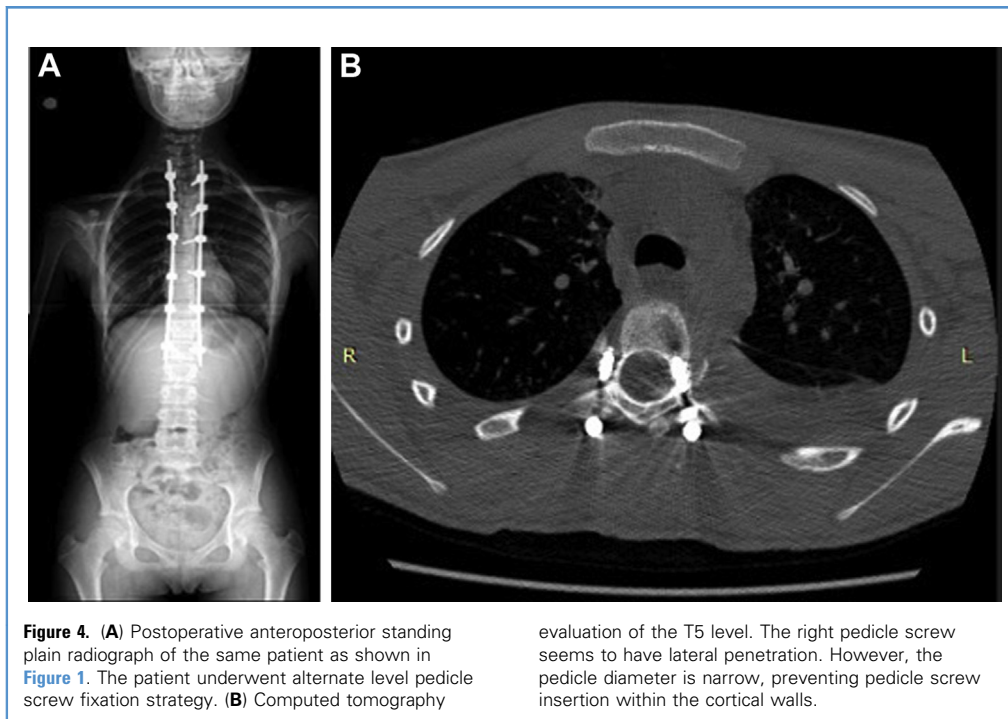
(A) Postoperative anteroposterior standing plain radiograph of the same patient as shown in Figure 1. The patient underwent alternate level pedicle screw fixation strategy. (B) Computed tomography
